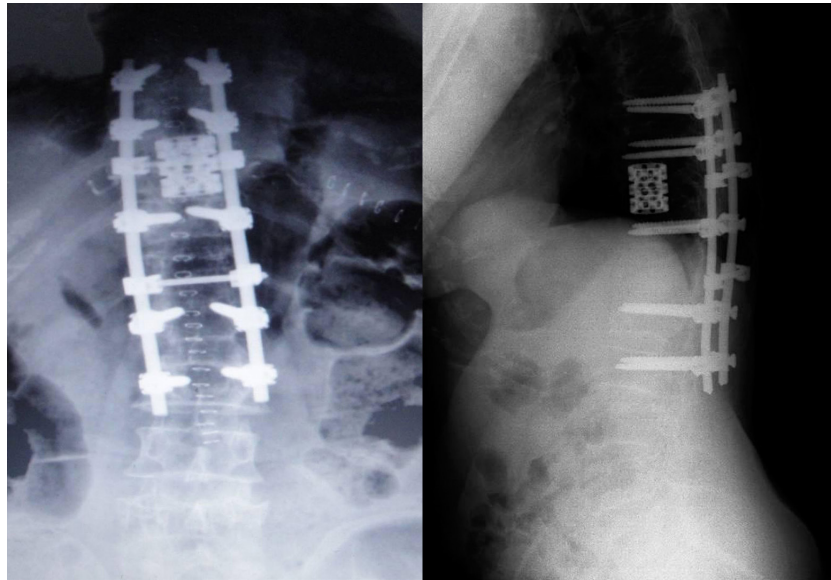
a) AP and b) lateral X-rays after T10 corpectomy.
